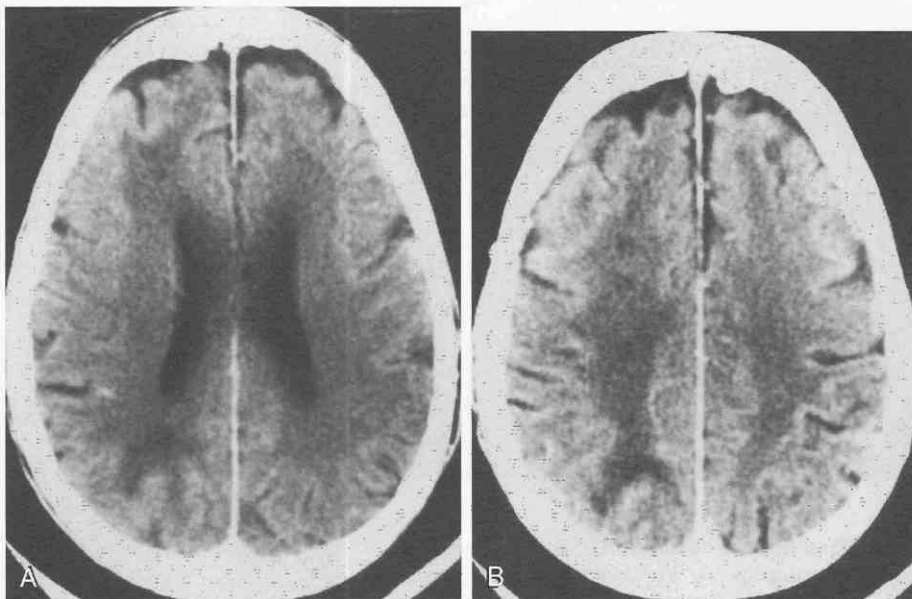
Deep watershed infarction mimicking primary leukoencephalopathy. Two CT images demonstrate right-sided white matter lesions, most prominent in the frontal and occipital region but confluent in the corona radiata. This represents ischemic leukoencephalopathy, secondary to acute deep watershed infarction. The CT scan had been normal 1 week previously at the onset of symptoms.
